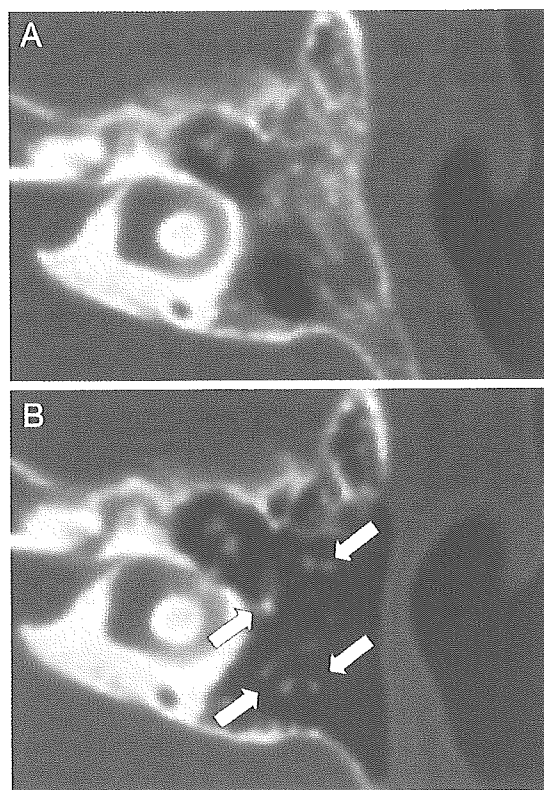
Computed tomography scan images of case 4, before and after surgery. (A) There are few air cells and little aeration in the mastoid cavity before the operation. (B) Eight months after the first-stage operation, aeration is completely recovered, and the pneumatic air cells are regenerated (arrows).
